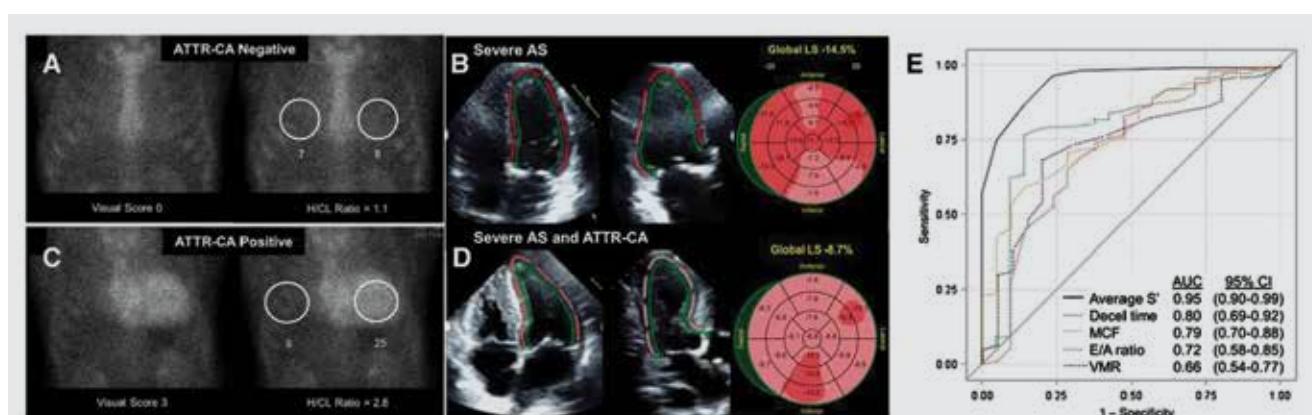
Take home figure. Transthyretin cardiac amyloidosis in patients with severe aortic stenosis. Panels A and B show the technetium-99m pyrophosphate (^{99m}Tc -PYP) cardiac scintigraphy and the left ventricular global longitudinal strain bull's eye plot of a patient without transthyretin cardiac amyloidosis. A ^{99m}Tc -PYP cardiac scintigraphy positive for transthyretin cardiac amyloidosis shows an increased heart-to-contralateral ratio (H/CL) (panel C) and more impaired left ventricular global longitudinal strain (panel D). Panel E shows the receiver operating curves for several echocardiographic parameters of left ventricular systolic and diastolic dysfunction. The S' measured on tissue Doppler imaging had the largest area under the curve to predict ^{99m}Tc -PYP cardiac scintigraphy positive for transthyretin cardiac amyloidosis. Reproduced with permission from Castano et al.⁵
